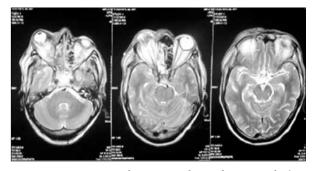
MRI scan report showing eye orbit involvement in the fungal infection: Entire volume of the disease is hypointense on both T2W & T1W images posterior, the disease extending up to the cavernous sinus with possible infiltration of the internal carotid artery.
